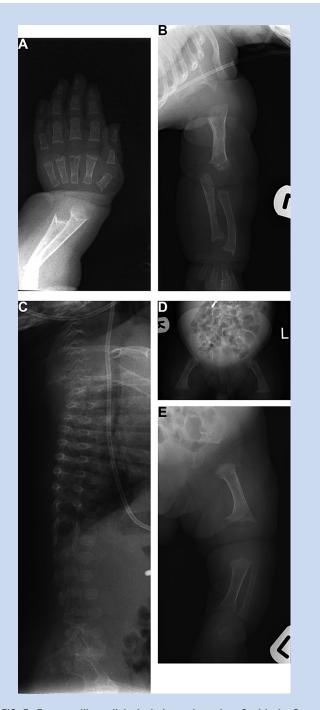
Torrance-like radiological picture in patient 3 with the Cterminal p.Thr1322lle mutation at the age of several months. A: Short and broad metacarpal and phalangeal bones, with broadening and cupping of the metaphyses. Spiking of the proximal metaphysis of the first metacarpal bone and of the distal metaphyses of the metacarpal bones 2–5. B: Short, squat bones of the left arm with broadening of the metaphyses and spiking of the distal radius and ulna. C: Ovoid vertebral bodies with mild beaking of L1. D: Short and broad pelvic bones with horizontal acetabular roofs and broad metaphyses of the proximal femora. E: Short, squat bones of the left leg with broadening of the metaphyses. being recorded, as 3, 7, 8, and 13 years, respectively. The relation between genotype and the severity of coxa vara (which could be assessed in 46 patients) and scoliosis is shown in Figure 8A,B, respectively. Although it was sometimes difficult to compare X-rays at different ages, the severity of the coxa vara tended to be consistent among affected relatives in familial cases.
